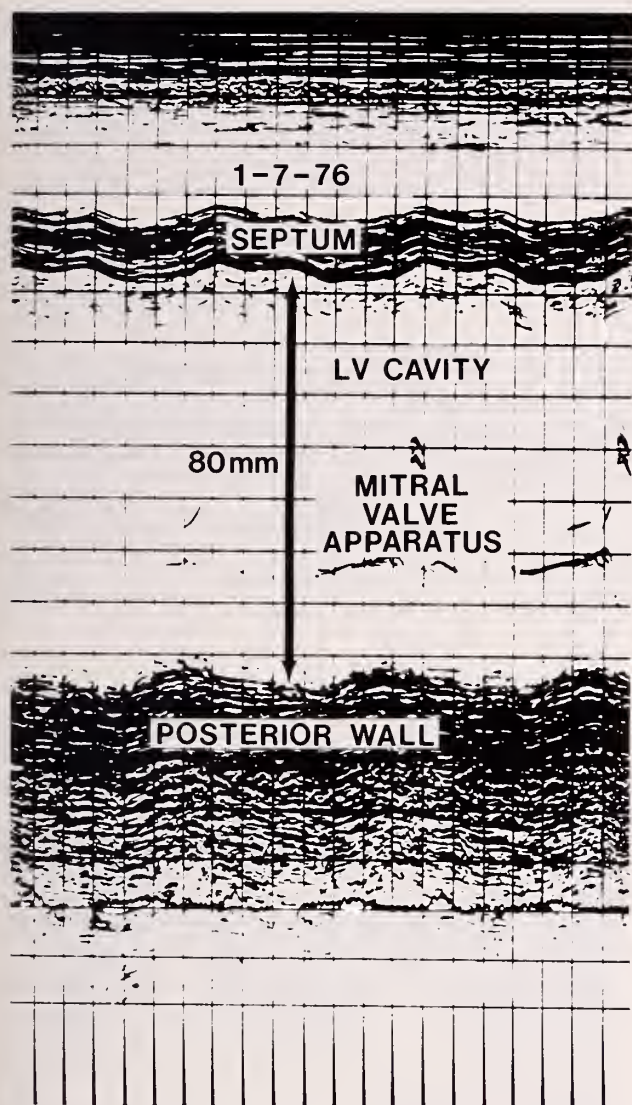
Preoperative Echocardiogram.
